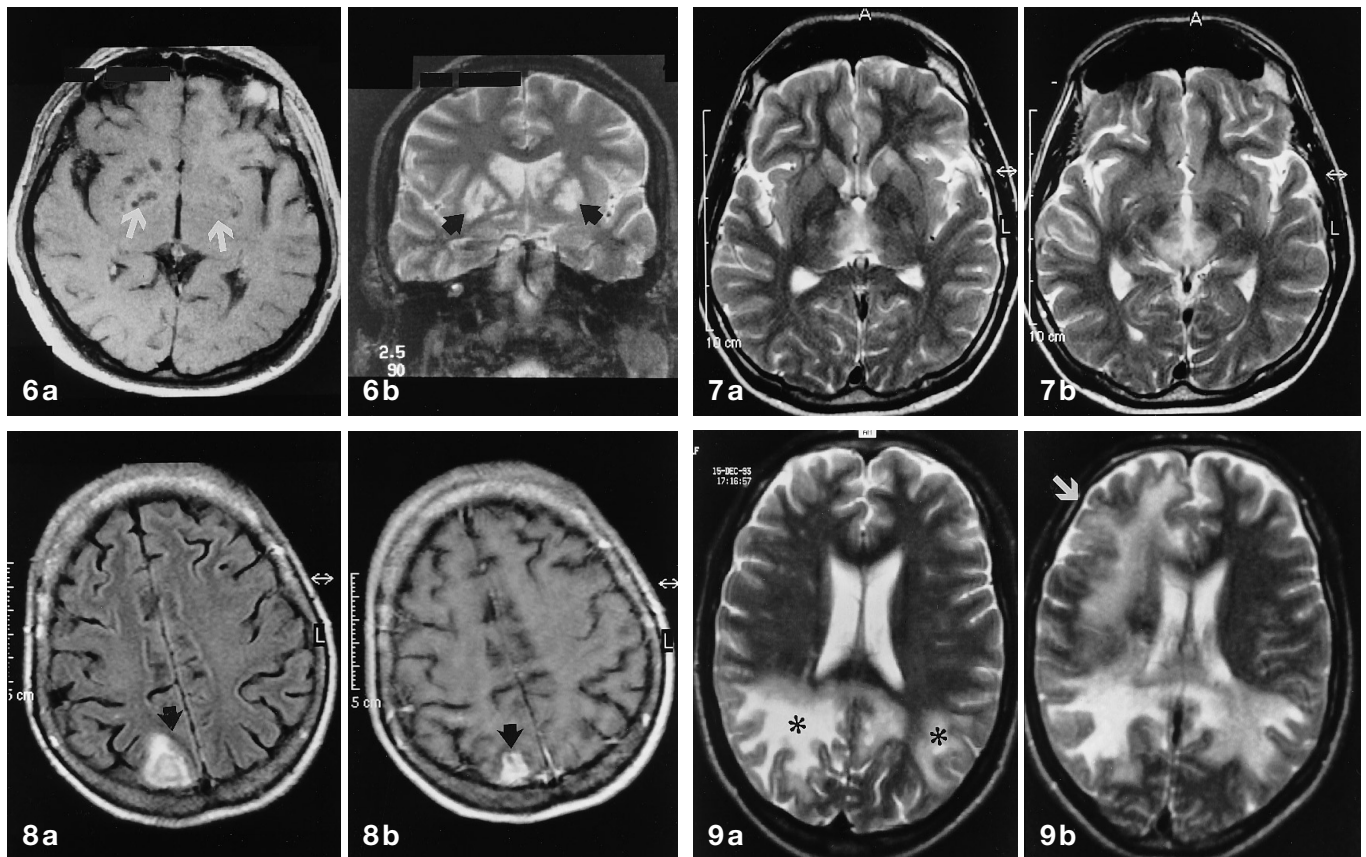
a, b. Cryptococcosis. a Axial T1-weighted (SE 700/19) MR image shows multiple cystic-like hypointense lesions (*arrows*) in both basal ganglia. b On corresponding coronal T2-weighted (SE 2500/90) MR image, clusters of punctate hyperintense foci bilaterally in the basal ganglia regions (*arrows*) were seen. These represent multiple dilated Virchow-Robin spaces filled with numerous fungi (proven by autopsy)
